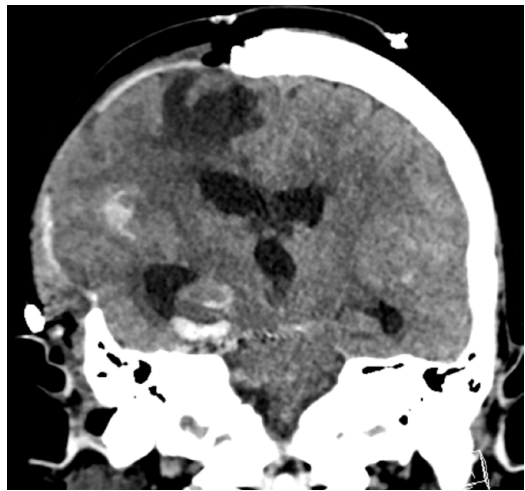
Postoperative CT scan after decompressive craniectomy following aSAH.
